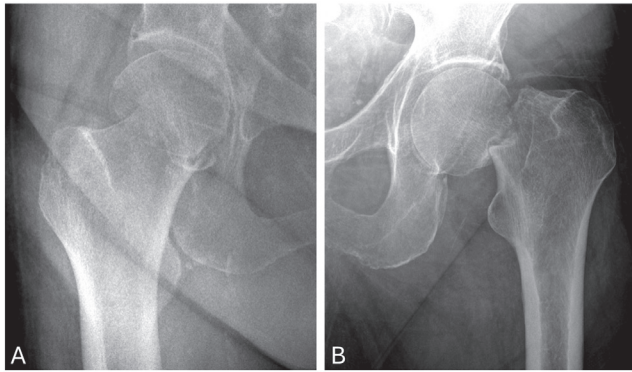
Preoperative radiographic images of (A) an 88-year-old female patient with a history of breast cancer and (B) a 71-year-old male patient with a history of prostate cancer, both diagnosed with incidental metastasis in the femoral head. Metastatic involvement does not always present with radiographic findings, such as sclerotic margins along the fracture line seen in patient B, and can be easily overlooked, as in patient A. A high index of suspicion should be maintained, particularly in patients with a history of malignancy.
